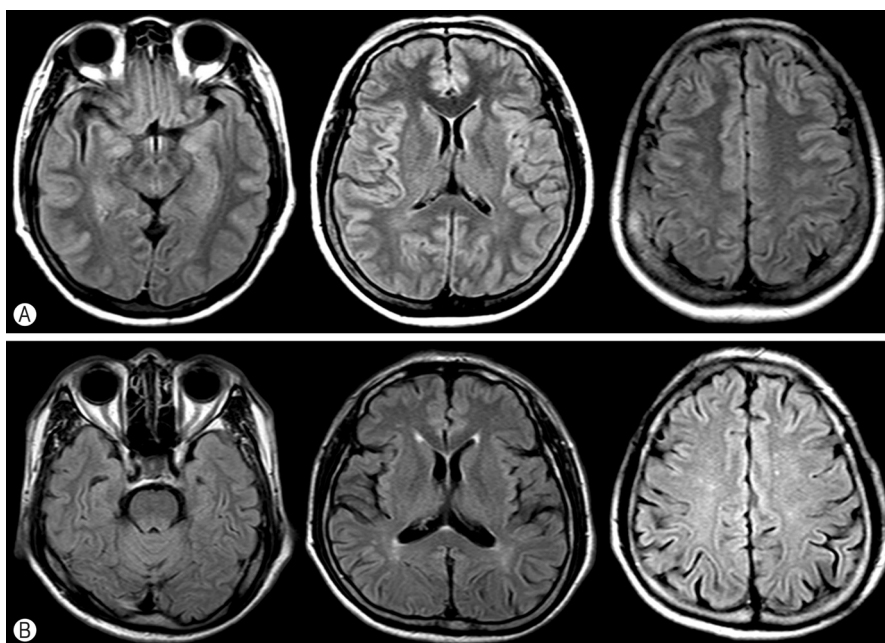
Brain magnetic resonance images. (A) Fluid-attenuated inversion recovery (FLAIR) axial images from case 1 were no significant brain atrophic change. (B) FLAIR axial images from case 2 showed mild ischemic lesions in periventricular white matter and mild atrophic change.
